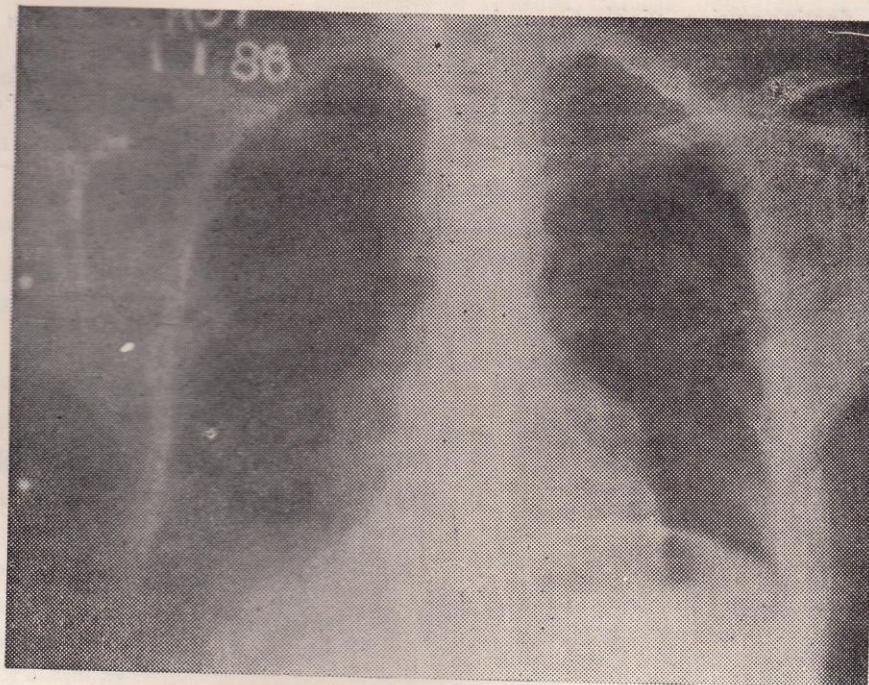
Post-operative and Post irradiation Chest X-Ray three months later*
